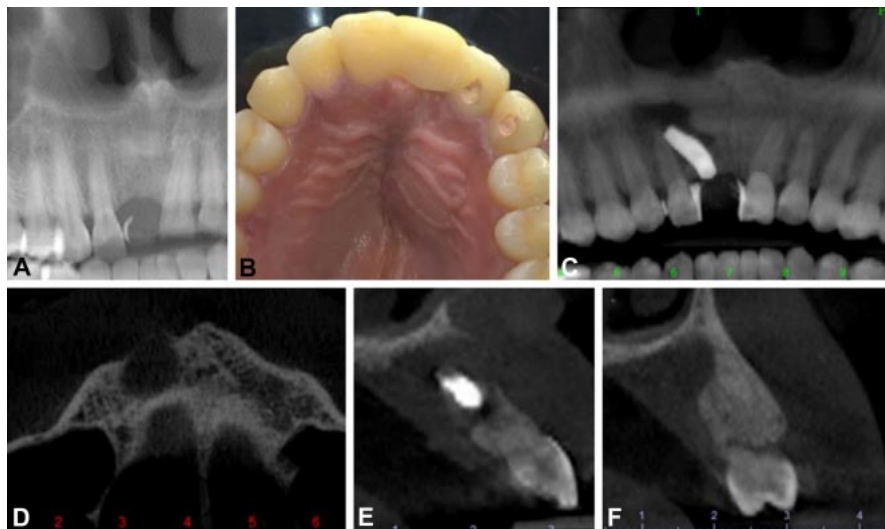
Initial condition of the peri-implant site. (A) Initial radiograph, two years before implant placement. (B) Gingival abscess condition and (C) computed tomography of the peri-implant contact with the dentinal root. (D) Axial image demonstrating buccal cortical destruction and integrity loss of the nasal floor, and (E) transverse images indicate contact of the apical region of the implant with the apical region of the dental element of tooth 12, (F) extending to the element 13.
